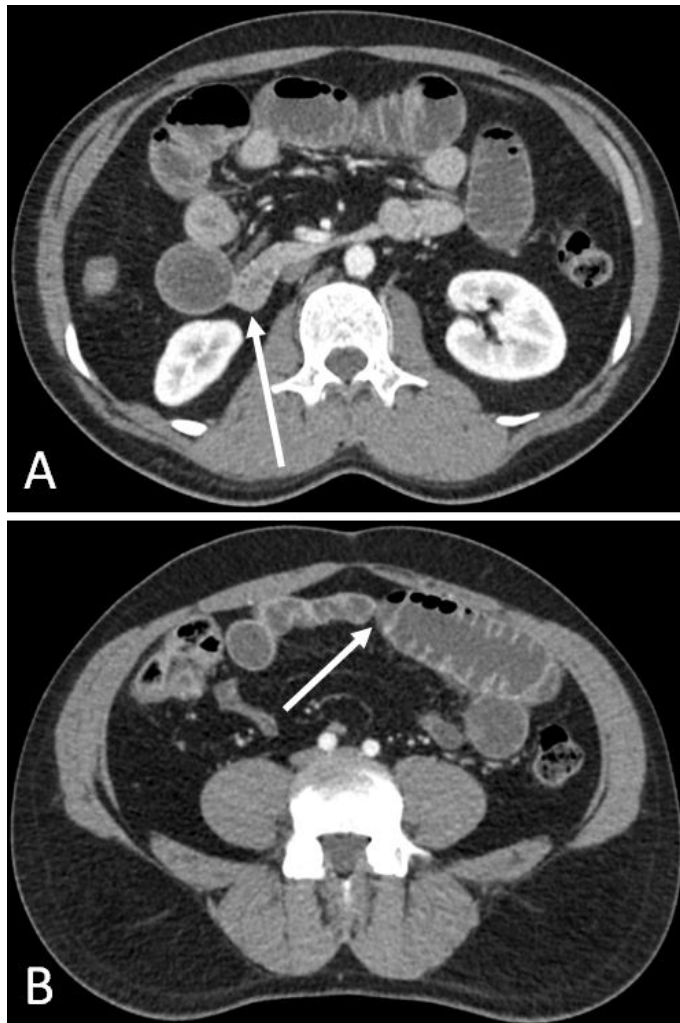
Axial view of abdominal computed tomography images showing the proximal (A) and distal (B) transition points (arrows) of a small bowel obstruction.
